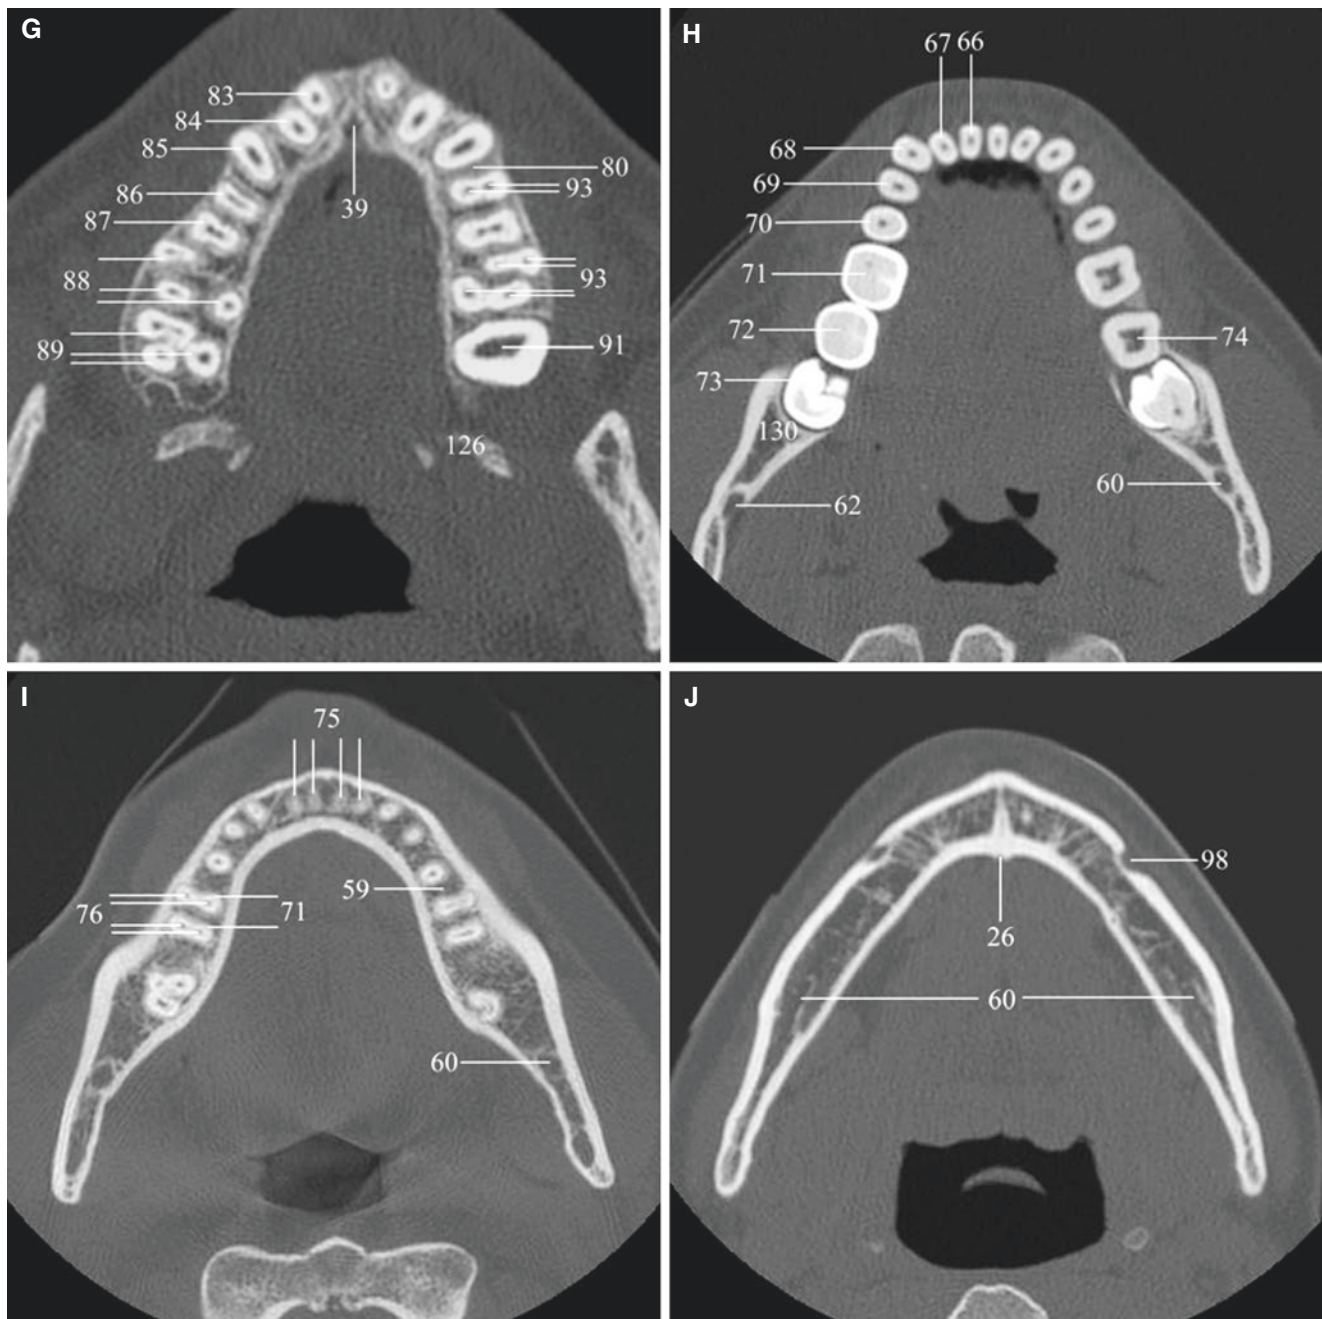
Normal bone anatomy of face; axial CT images from superior (A) to inferior (J)
